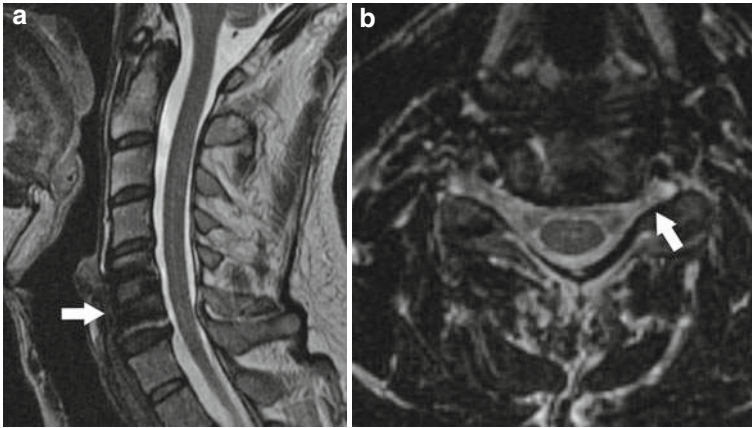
Osteoarthritis. Cervical spine MR sagittal T2-weighted image (a) reveals anterior fusion hardware (*arrow*) at the C5–6 level. Axial T2-weighted image (b) reveals left C5 nerve root foraminal narrowing (*arrow*)
